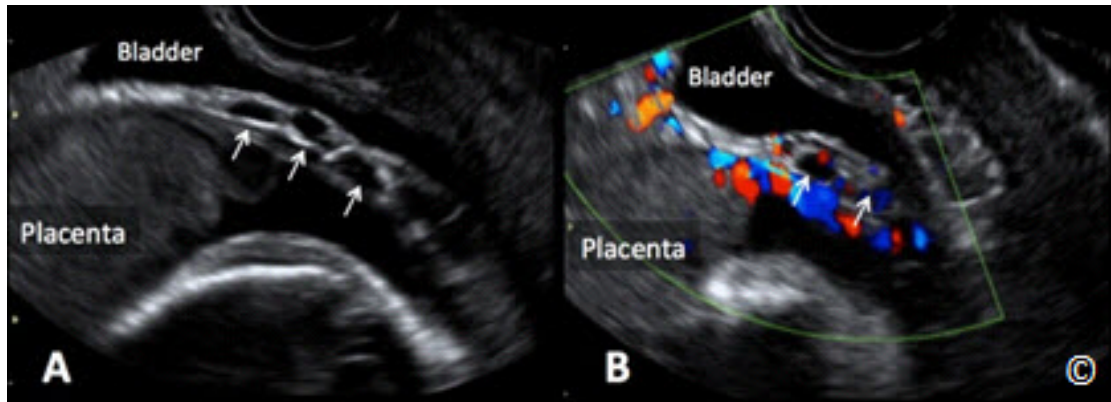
A and B: Transvaginal ultrasound in grey scale (A) and color Doppler (B) in a pregnancy with an anterior placenta accreta with abnormalities of the uterine serosa-bladder interface. Note the presence of abnormal vascularity in the posterior wall of the bladder (A and B - arrows). Placenta and bladder are labeled.
